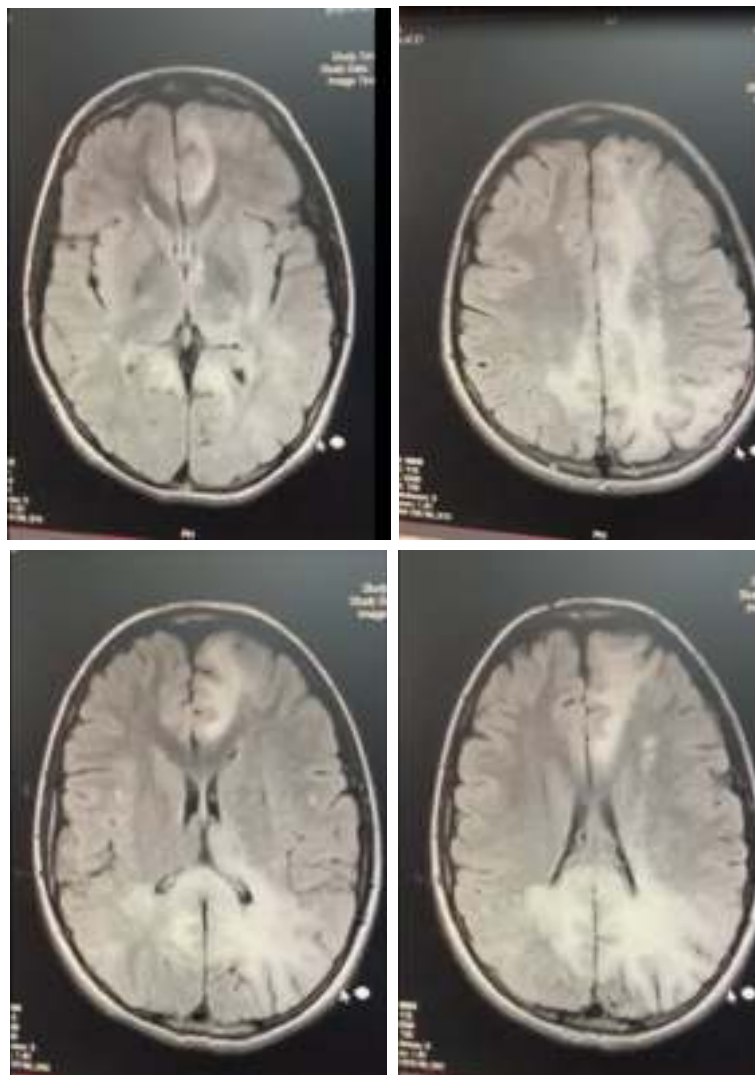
MRI of the patient's brain in the course of the disease shows large confluent non-enhanced, infiltrative, ill-defined, subcortical, and cortical mass lesions, involving the left hemisphere, which crosses the midline to involve the right hemisphere via the splenium of the corpus callosum.
